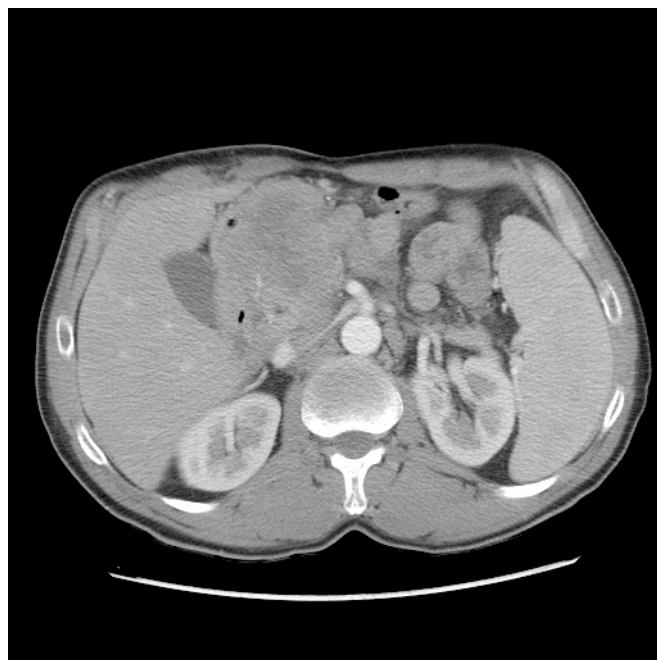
Control CT scan revealing large mass in the pancreatic head, up to 9.5 cm, with duodenum infiltration and superior mesenteric vein thrombosis, suggested to be a neoplasia
